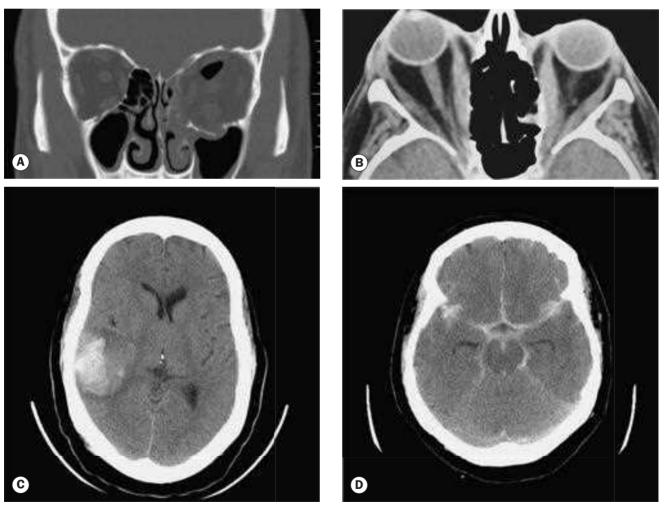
CT scans. (A) Coronal image showing blow-out fractures of the left orbital floor and medial wall with orbital emphysema; (B) axial image showing bilateral enlargement of extraocular muscles and right proptosis; (C) axial image showing an acute parenchymal haematoma in the right temporal lobe; (D) axial image showing extensive subarachnoid blood in the basilar cisterns, and the Sylvian and interhemispheric fissures (*Courtesy of N Sibtain – figs A, C and D; A Pearson – fig. B*)
